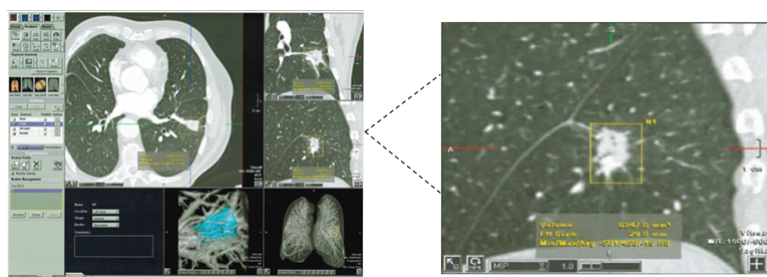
Calculation volume example on magnetic resonance imaging (MRI) medical image by Vitrea Advanced.
